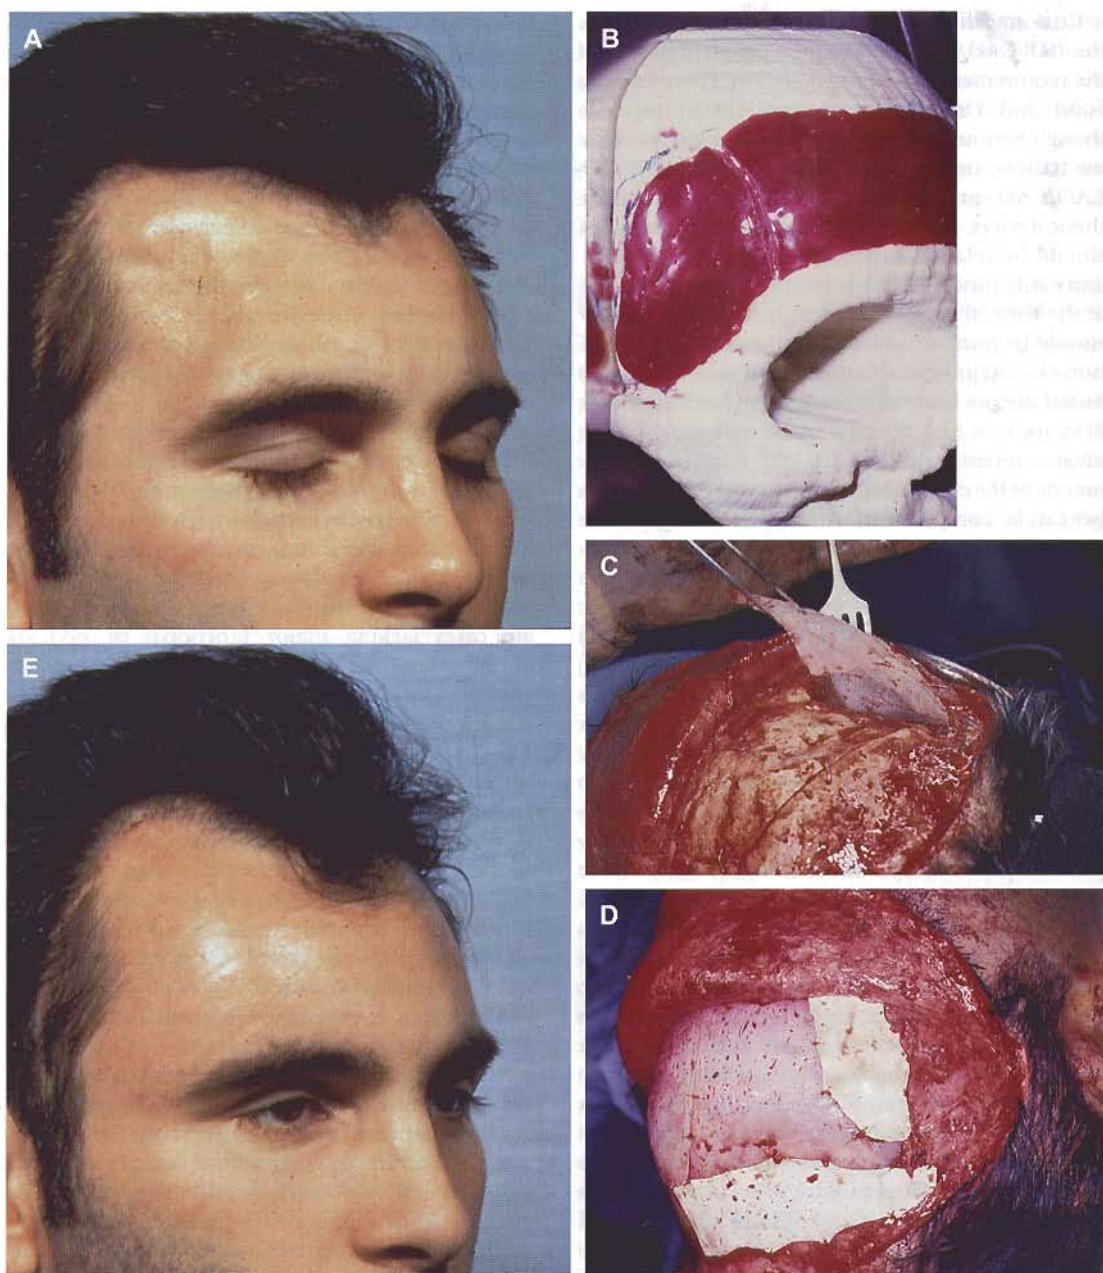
A 28-year-old patient presented with a complex posttraumatic defect secondary to bone loss and muscle atrophy over the right frontal and anterior temporal region of the skull 2 years after two life-saving craniotomies had been performed. (A) Preoperative photograph. (B) Frontal view of the model with the initial template designed and molded on the anatomic model derived from 3D CT imaging. The template is formed to fill the frontal and temporal bone defect and also is designed to compensate for the atrophy of temporalis muscle within the temporal fossa. (C) Intraoperative view of the reconstruction of the entire frontal and temporal defects with the use of the custom implant. (D) Because of the absence of periosteum within and around the defect, two biomaterials (silicone rubber and expanded polytetrafluoroethylene) were used simultaneously to bridge the area of bone and to fixate the large implant to the surrounding soft tissues. (E) One year postoperatively the area is restored to a completely smooth and symmetric contour. To date, the results have been unchanged and without complication for over 14 years.
